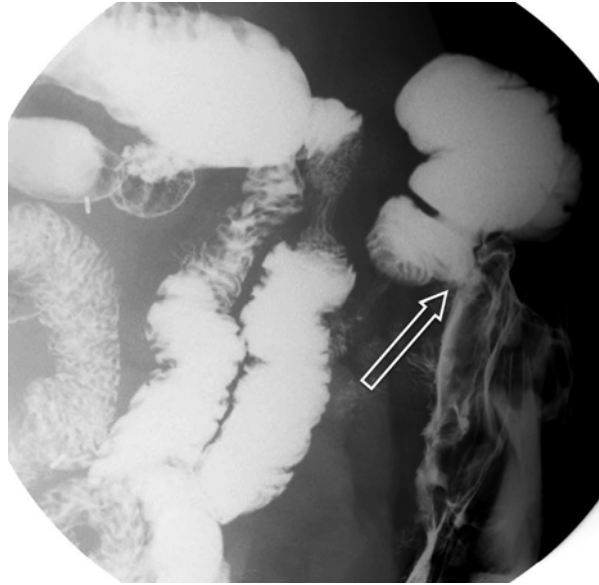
Plain film image of a fistulogram in a 23-year-old male with history of gunshot wound to the abdomen and ileostomy depicting an enterocutaneous fistula communicating with the jejunum and antegrade flow of the contrast towards the ileostomy site. The contrast opacification pattern suggests the fistula arising from the mid jejunal loops, proximal to the ileostomy. Of note, the image also shows the patients hand; he was asked to hold the catheter firmly during injection of the contrast
